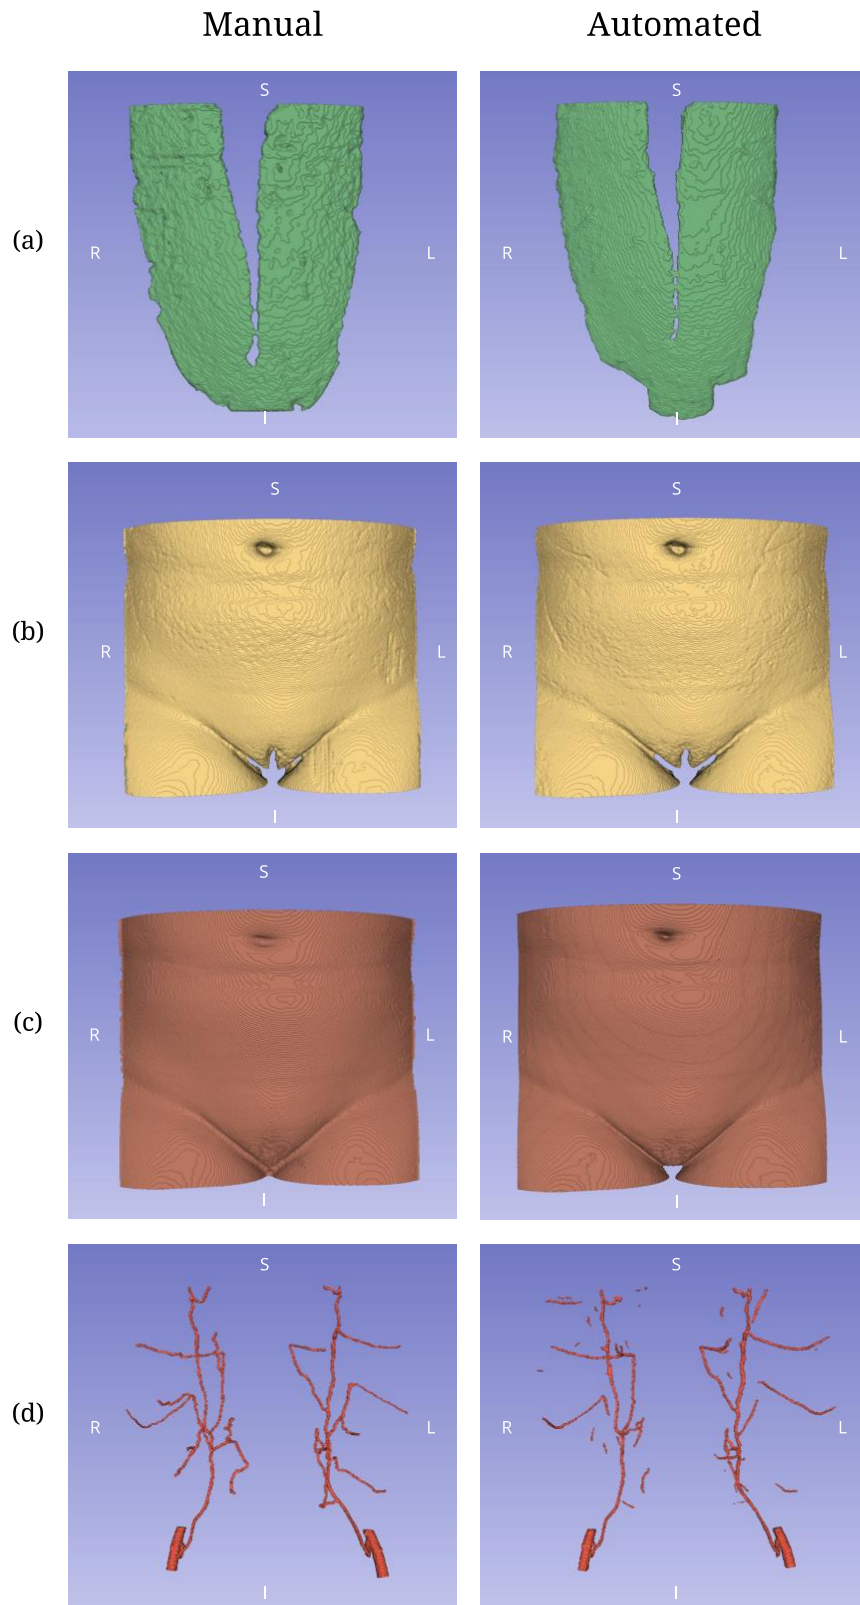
Visualization of the manual and automated segmentations of the (a) Rectus Abdominis muscle, (b), fat tissue, (c) skin tissue, and (d) deep inferior epigastric artery perforators for the CTA scan of one patient.
